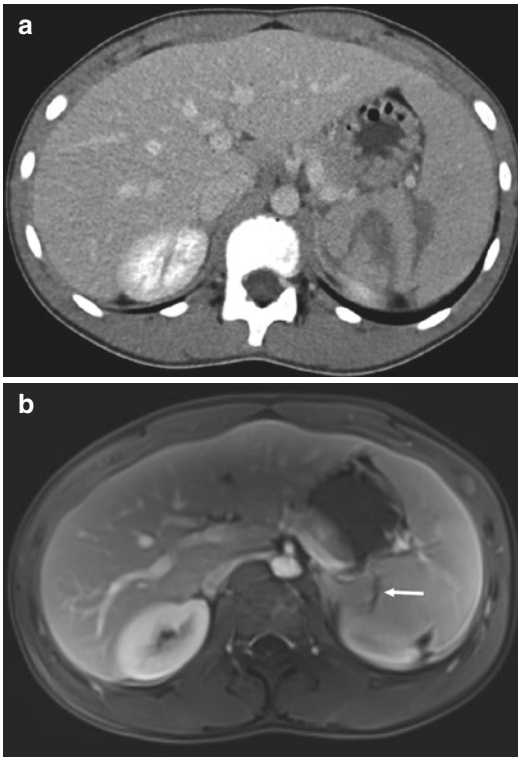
Fourteen year old boy. (a) CT with contrast: Grade III splenic trauma. (b) MR with contrast: Long term follow-up by MRI to avoid ionizing radiation with rapid gradient echo T1 weighted sequence with gadolinium a linear parenchymal sequelae (white arrow)
